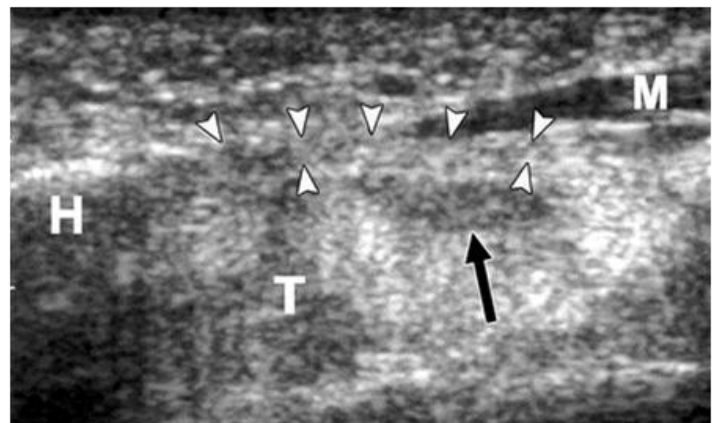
Axial sonogram of the cross-section of the median nerve at the carpal tunnel outlet. The arrowhead shows the flexor retinaculum and the arrow shows the median nerve.
